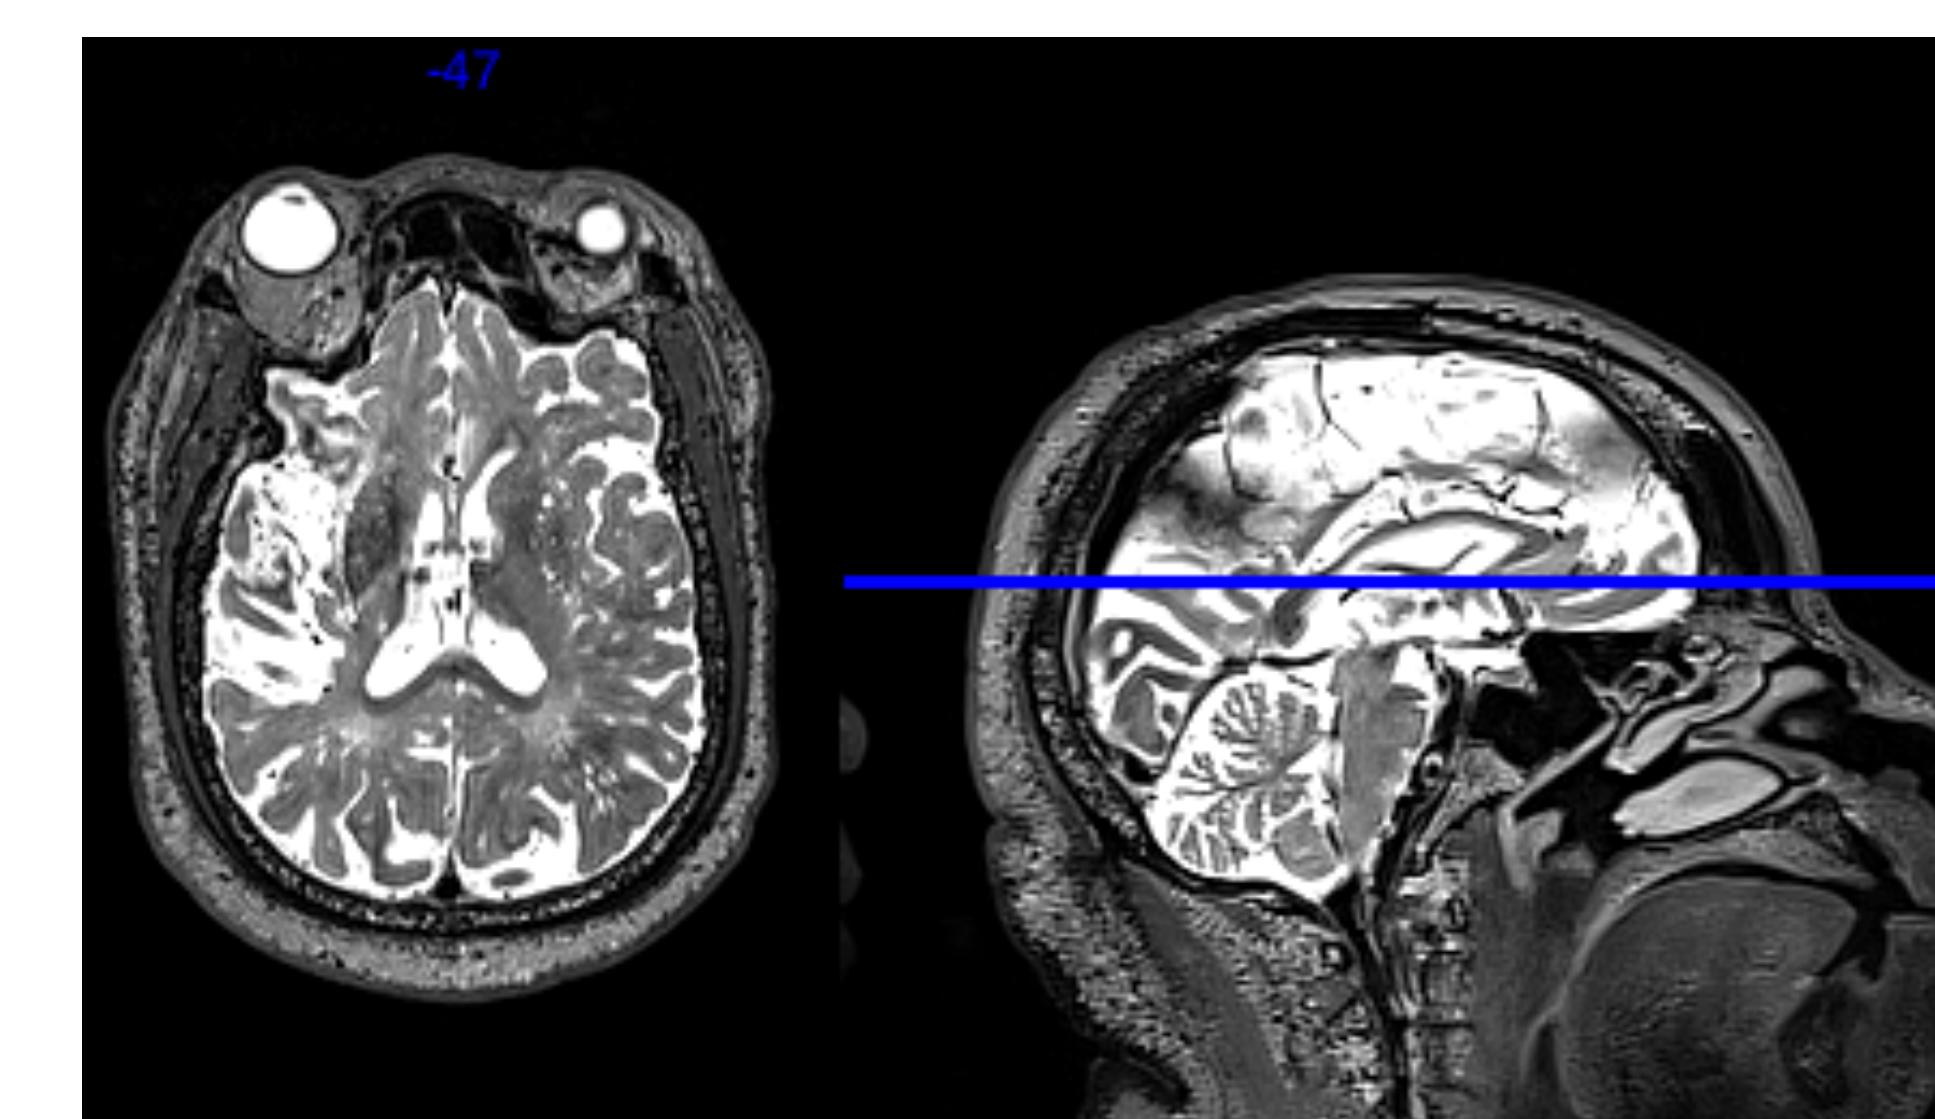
T2-weighted MRI showing moderate-severe leukoaraiosis.
